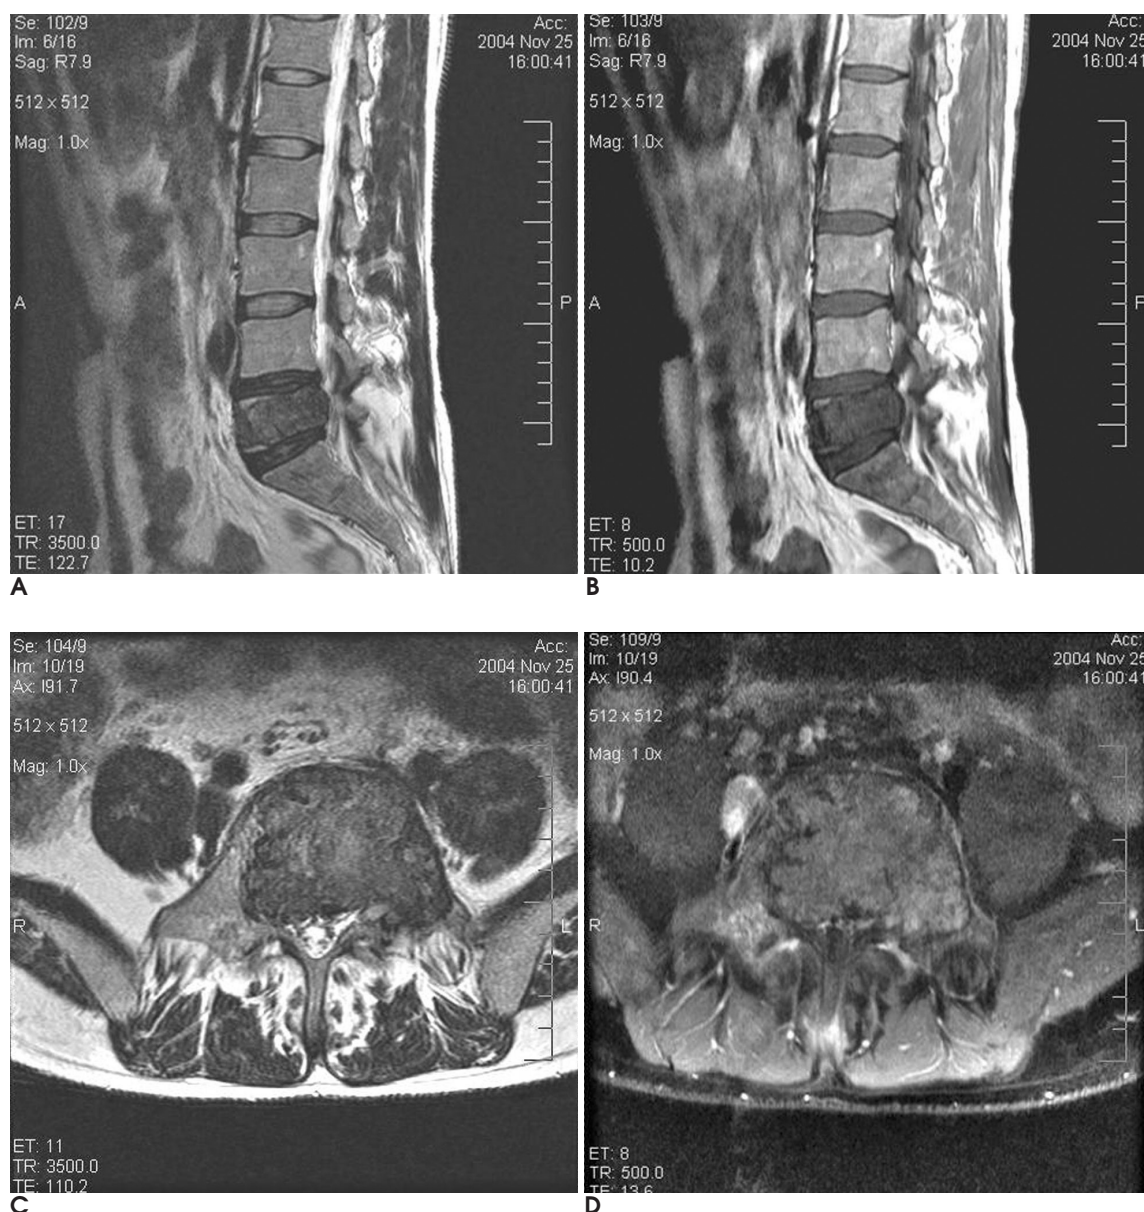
MRI in 43-year-old man with brown tumor of the spine.
